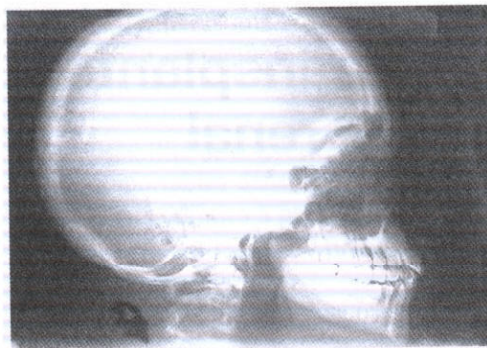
Skull X-ray: shows pepper pot appearance with generalized osteopenia
